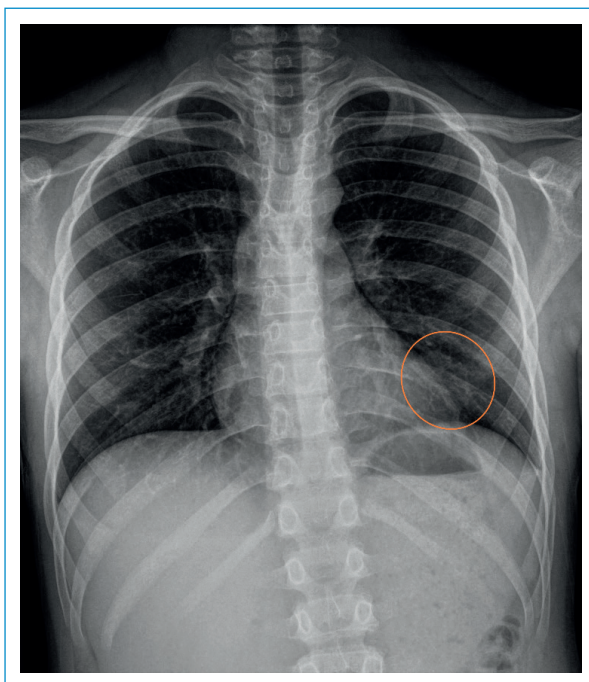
PA chest x-ray revealed subtle left paracardiac opacity while preserving the left cardiac border.
